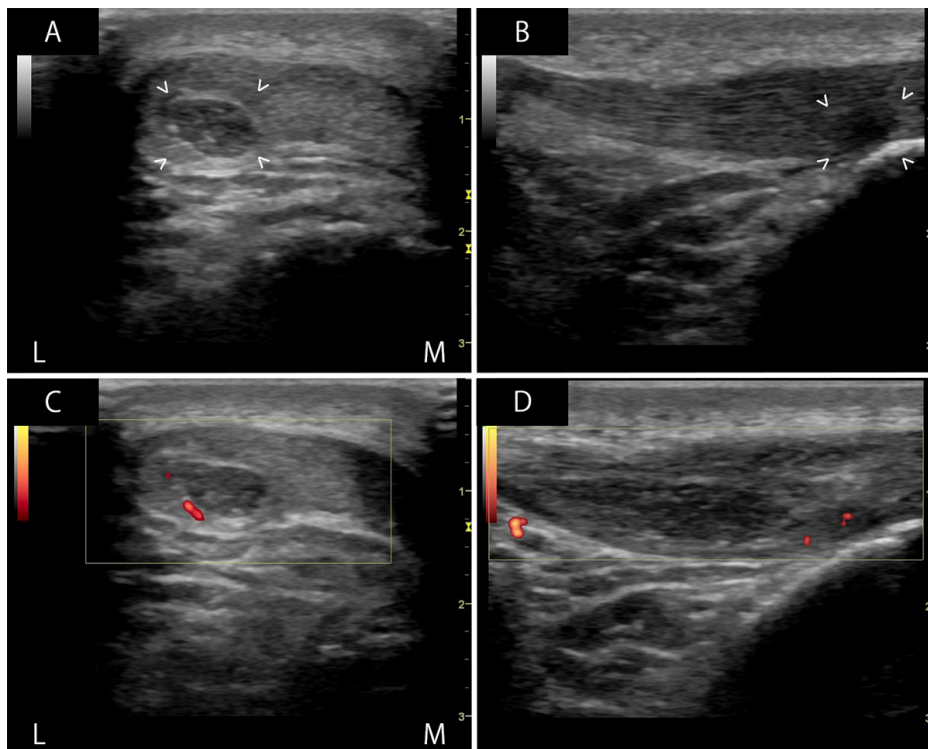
Lateral and short axis ultrasonography of the right patella tendon at 4 weeks. A and B: The area of injury is almost fully filled and is well defined (\wedge) compared to the normal tendon architecture. This is most evident on the short axis. C and D: Compared to the ultrasound images taken at 2 weeks, there is a slight increase in vascularity and it was attributed to the commencement of physiotherapy.
